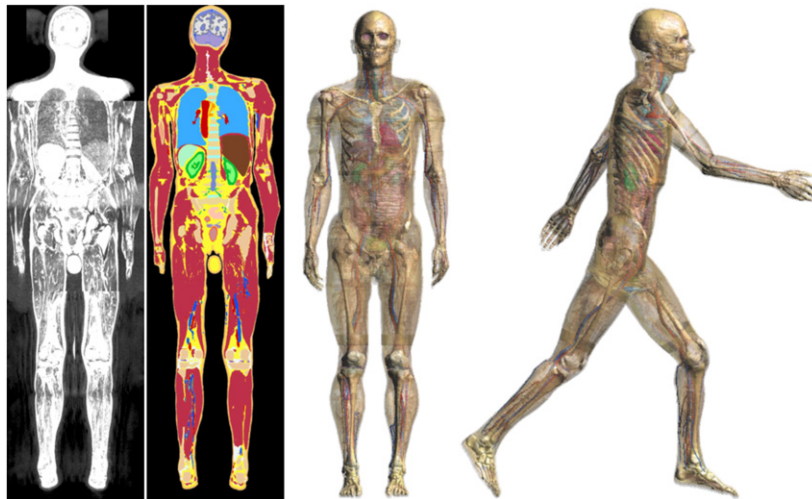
From left to right: raw MRI data, label-fields, surface model, and posed model (generated using the posing functionalities described in section 2.2.2).
